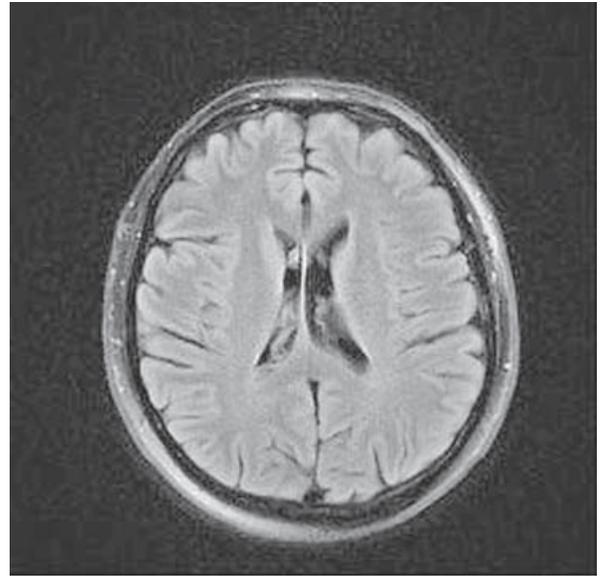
Control axial FLAIR MRI shows normal findings.
